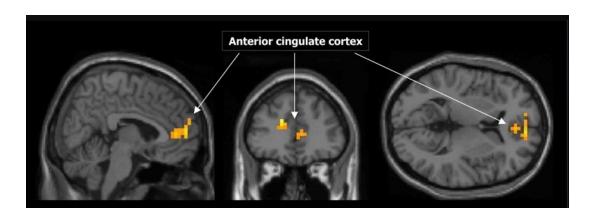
Anterior Cingulate Cortex on functional Magnetic Resonance Imaging (165).
